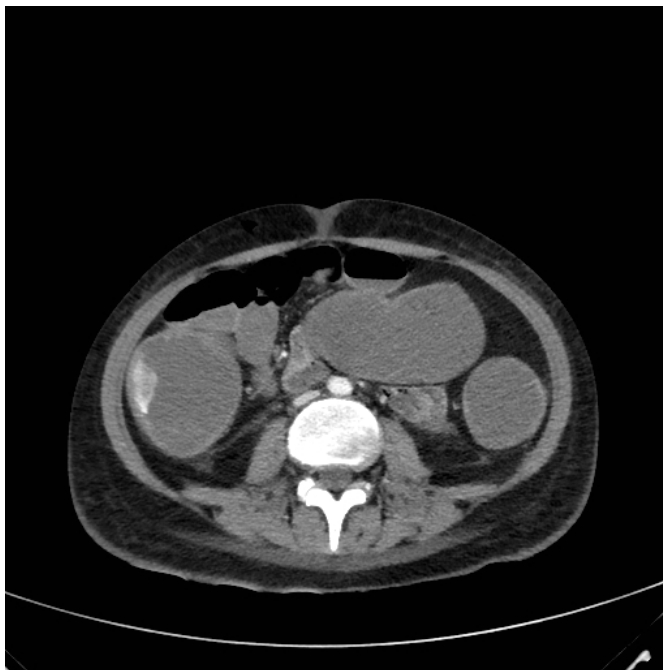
Axial contrast-enhanced CT scan of the abdomen showing active extravasation of intravenous contrast in the ascending colon, indicating active lower gastrointestinal bleeding.
